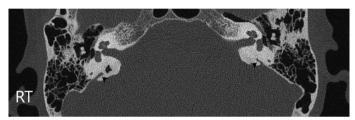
Axial non-contrast enhanced high-resolution computed tomography (CT) of the temporal bones. RT indicates the right side. The black arrows point to the right and left vestibular aqueducts. Note the enlarged vestibular aqueduct measured 1.2 mm on the right.
